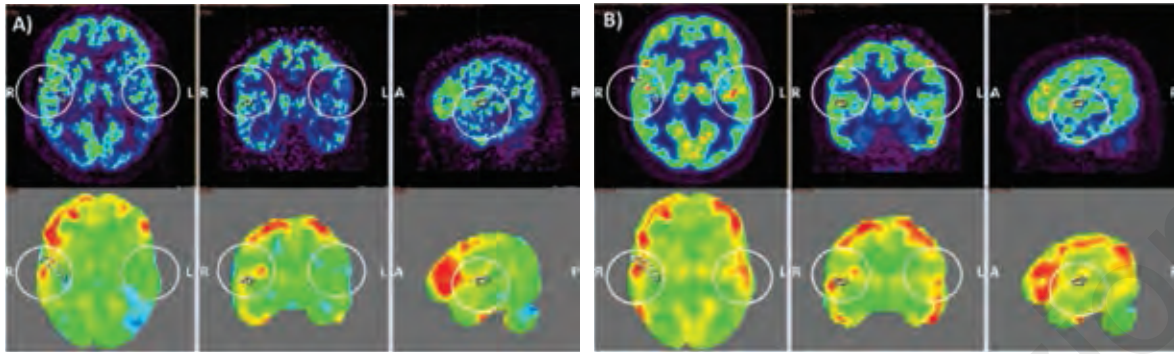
Auditory cortical activation and plasticity after cochlear implantation measured by PET using fluorodeoxyglucose. PET scans of the brain showing Heschl temporal gyri at the time of cochlear implant activation (panel A) and after 2 years of cochlear implant use (panel B) in one example case (patient #4). The main changes in cortical activation after cochlear implantation are observed mainly in the temporal areas, as presented here in the Heschl temporal gyri (marked with white circles for easier identification). The increase in regional tissue concentration of FDG in subsequent trials was clearly notable in the left-sided structures, which means that the left side of the auditory cortex was preferentially activated by listening to speech stimuli.
